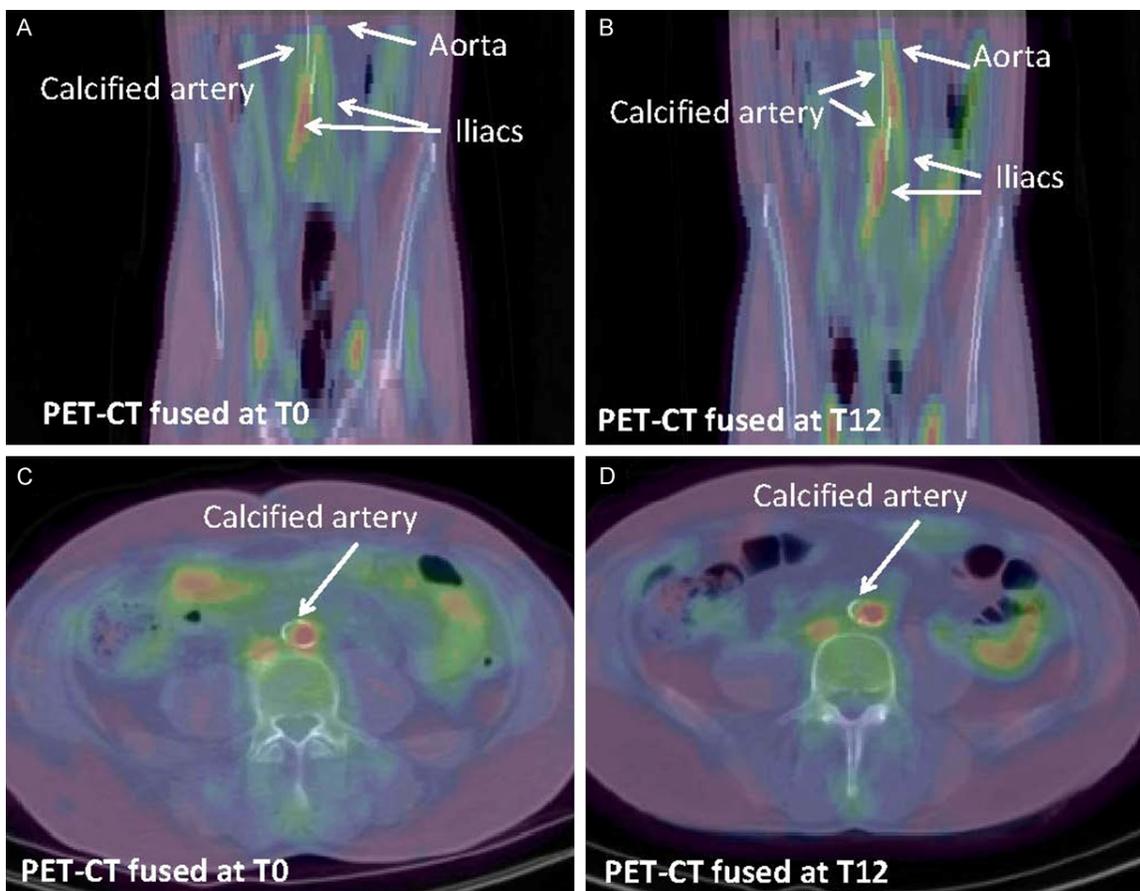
Coronal and transaxial PET-CT images at T0 (A, C) and at T12 (B, D). Arrows indicate calcified segments of the aorta. Fusion of PET and CT shows that ^{18}F -FDG uptake is mostly located in the calcified segments of the arteries suggesting inflammation in the atherosclerotic plaque. (A) Coronal fused PET-CT at T0, (B) Coronal fused PET-CT at T12, (C) Transaxial fused PET-CT at T0 and (D) Transaxial fused PET-CT at T12.
